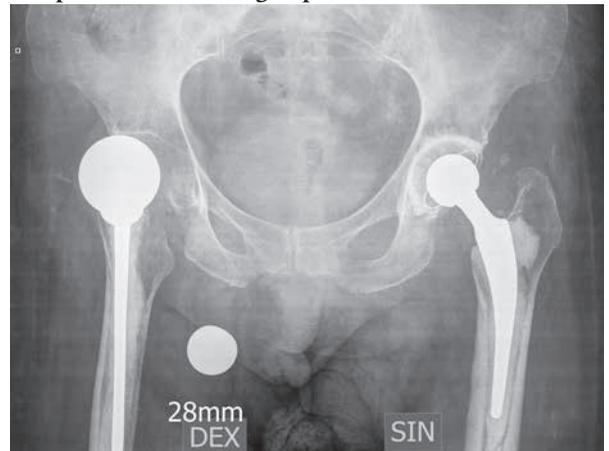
Pelvic X-ray- malposition and subluxation of the right unipolar prosthesis and cemented total left hip prosthesis
